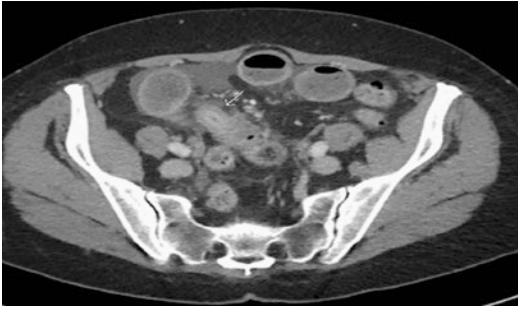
Axial CT image showing acute appendicitis with thickened appendiceal wall (arrow) and surrounding fat stranding
